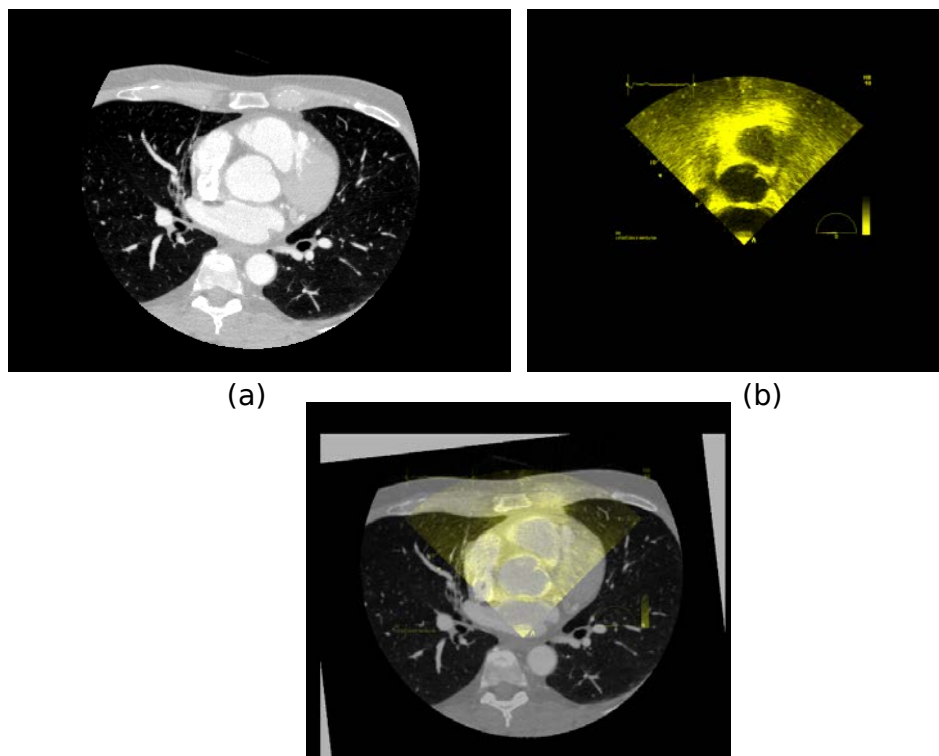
a) US Image 1. b) Resampled CT image. c) Result of the our proposed registration.
